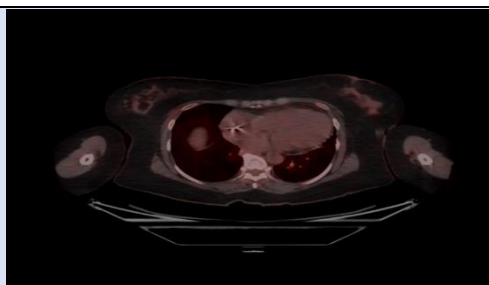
FDG PET/CT scan image, axial view at the heart level shows no FDG hypermetabolism in the myocardium indicating no active sarcoidosis at the heart.
